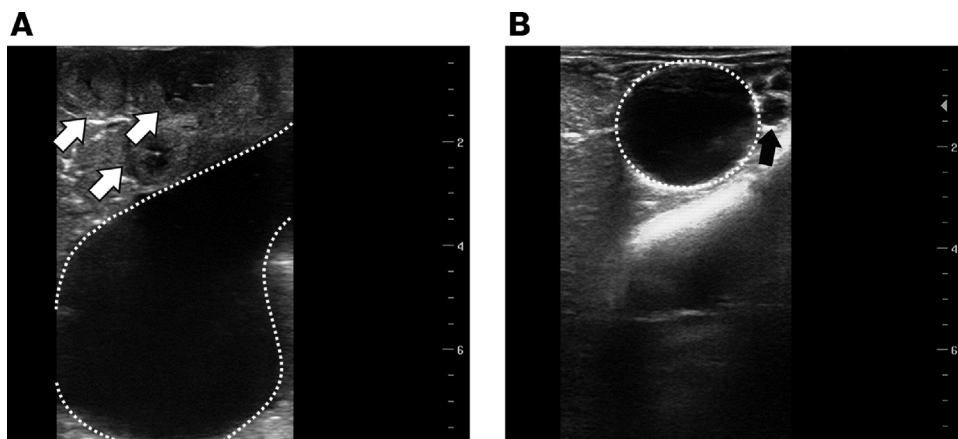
Ultrasound images characteristic of hydro-salpinx, which is characterized as a rounded, anechoic structure (dashed line), formed by the accumulation of fluid in the lumen, positioned: (A) lateral to transverse cuts of the uterine horn (white arrow) showing normal echogenicity and morphology; (B) next to the ovary containing several follicles (black arrow).
